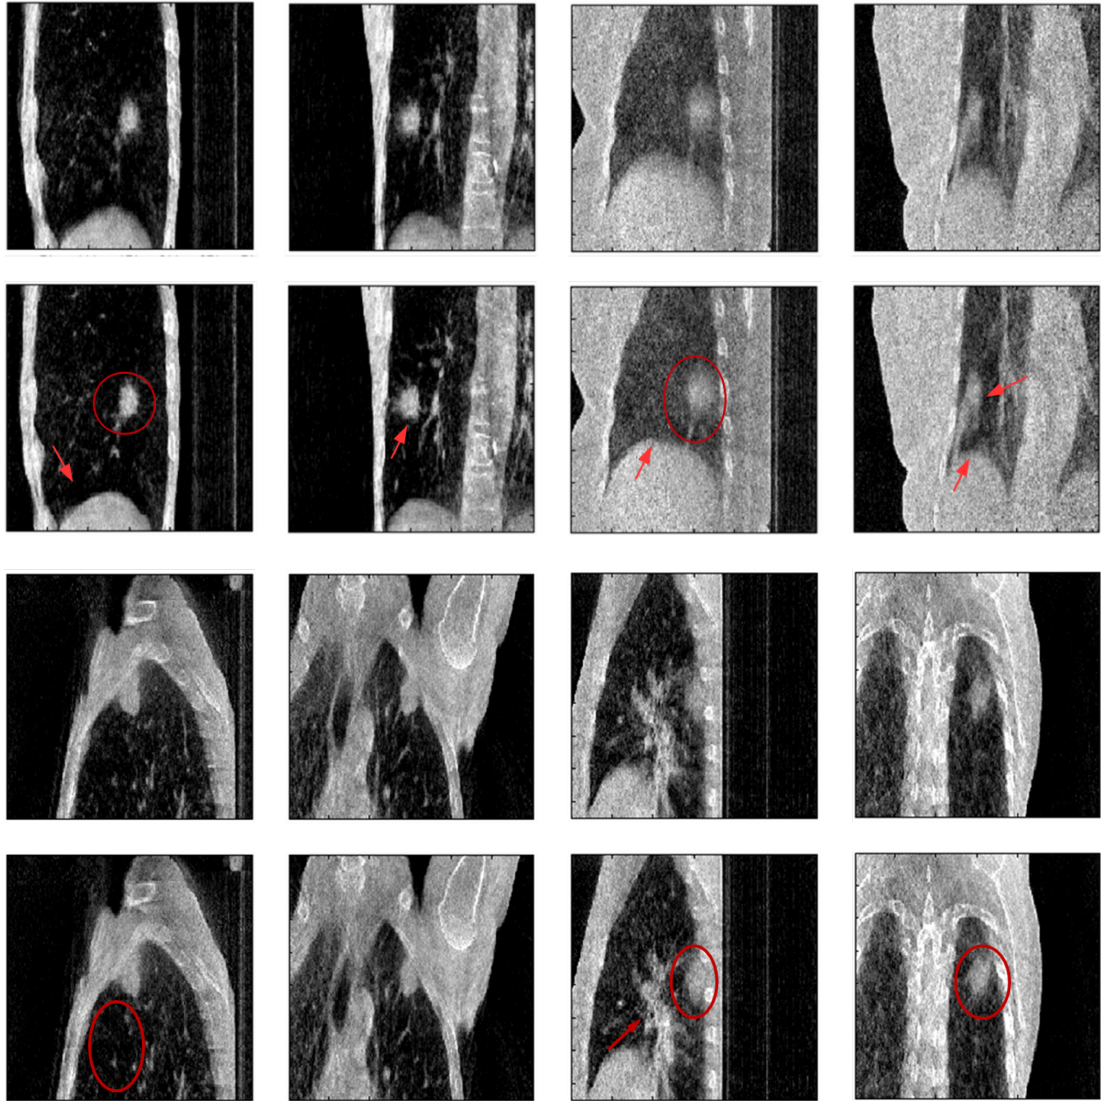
Sagittal and coronal slices of patients 1 (bottom left), 2 (top left), 3 (top right) and 4 (bottom right). For each patient, reconstructions without (top row) and with fitted (bottom row) motion correction are given. Patients 2 and 3 exhibited the most motion. Slice position intersects with isocentre of the CBCT scanner, which is approximately aligned with the tumour region. Red arrows and circles indicate areas of improvement with motion correction.
